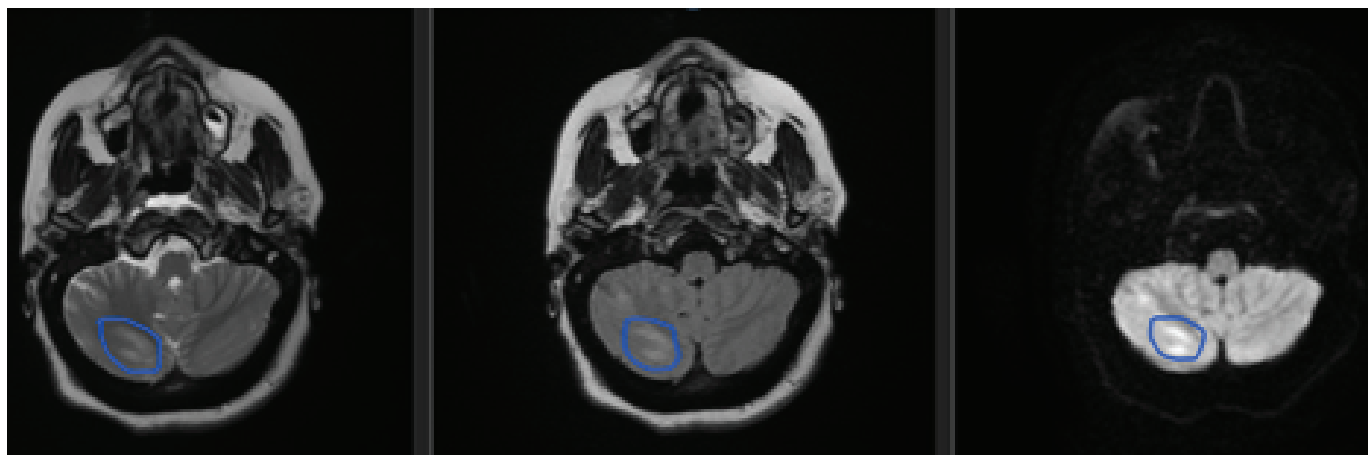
MRI Scan Brain (with FLAIR) Showing Hyper-Intense Signals in Right Cerebellum.
